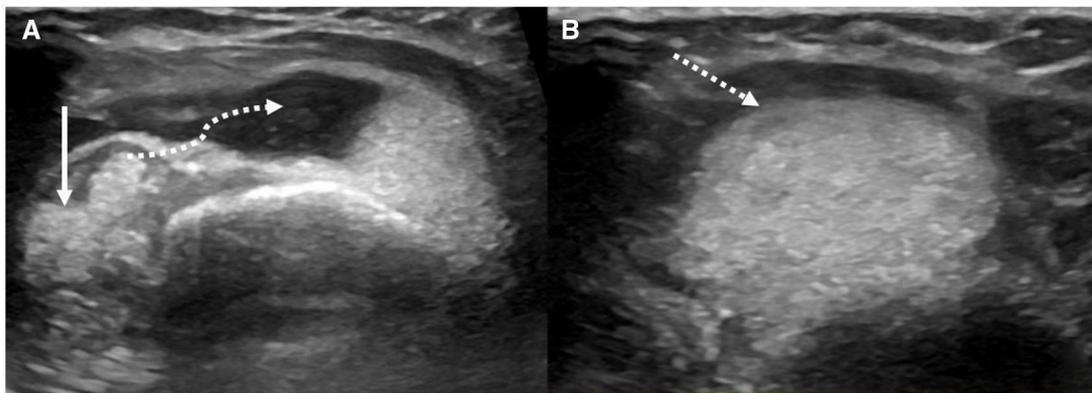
Ultrasound images of the shoulder in transverse plane (A and B) showing supraspinatus calcific tendinopathy (white arrow) with migration of calcium (curved dashed arrow) into the subacromion subdeltoid bursa with homogenous hyperechoic bursal fluid giving an appearance of milk of calcium (dashed arrow), please note fluid-fluid level due to sedimented calcium in the dependent area of the bursa.
